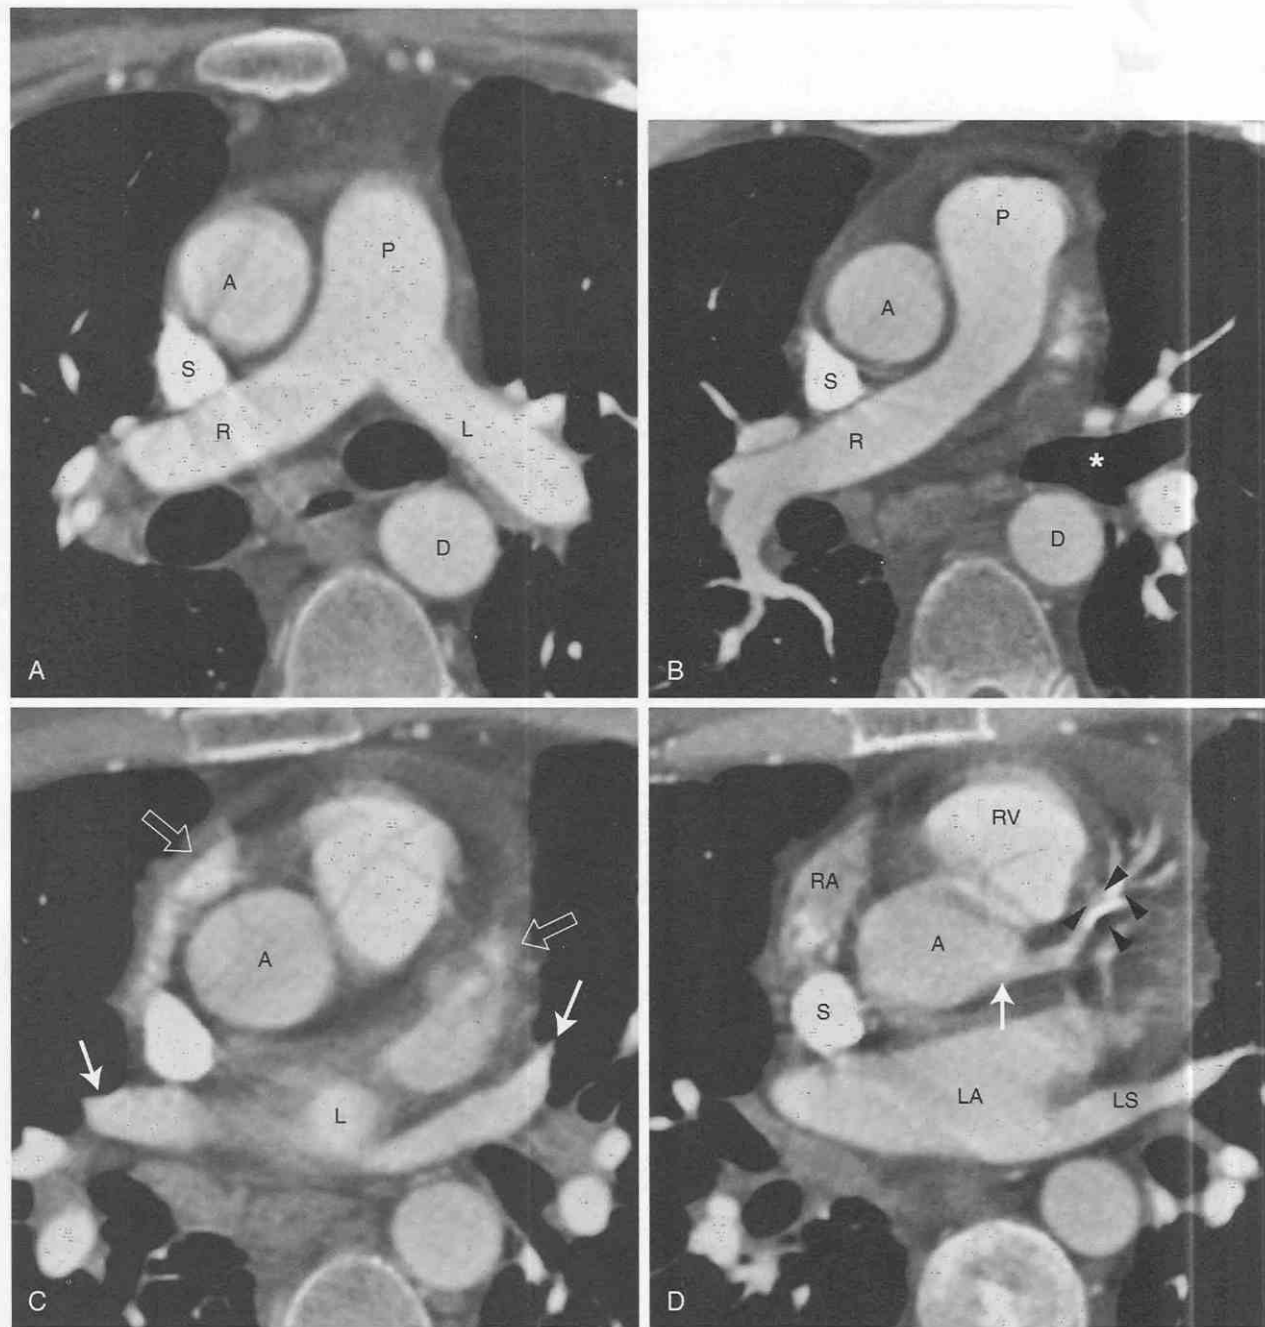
Normal anatomy. Axial contrast-enhanced CT images from the level of the pulmonary arteries (A) to the level of the inferior aspect of the heart (D) display normal cardiac anatomy.
